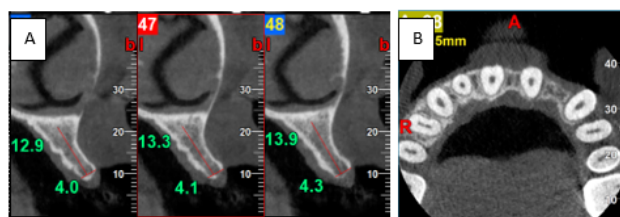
(A) CBCT section wrt left lateral incisor (Tooth no. 22) (B) CBCT section – Occlusal view
